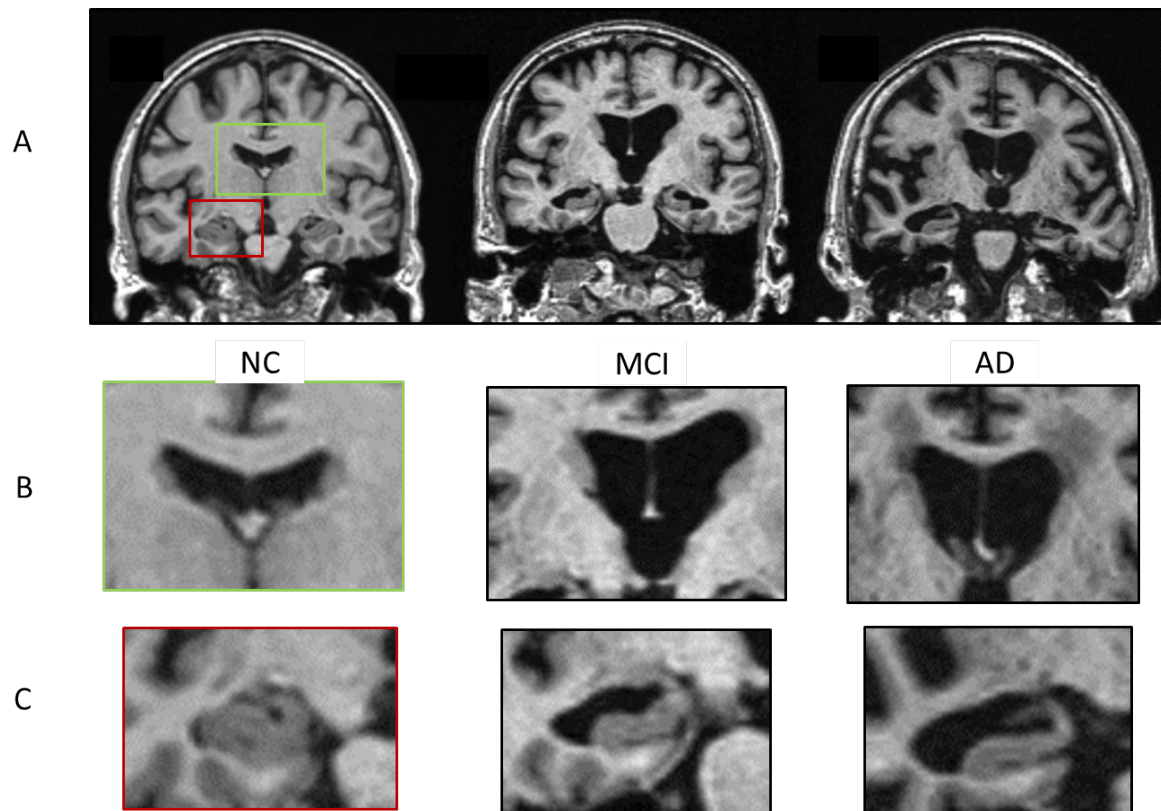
A: T1-weighted MRI scans (1.5 Tesla) of an older cognitively normal (CN) subject, a Mild Cognitive Impairment (MCI) subject, and an Alzheimer's disease (AD) subject in three cases (NC, MCI and AD). B: Lateral Ventricles enlargement (Green). C: Progressive atrophy of Hippocampus structure (Red).
